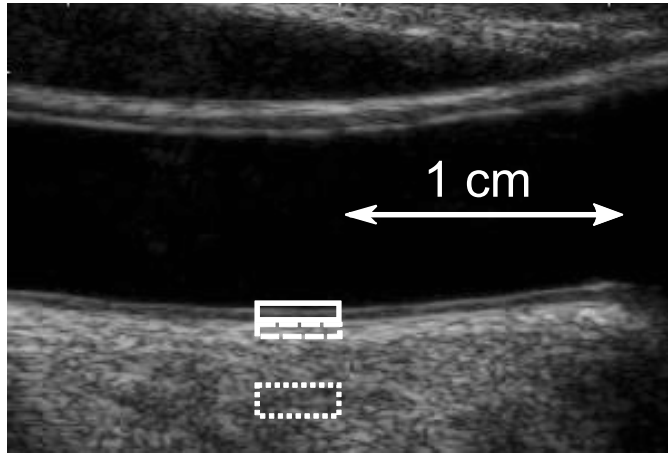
Ultrasound image of the common carotid artery. The typical locations of the regions of interest (ROI) used in the longitudinal motion-tracking are 1 cm before carotid bifurcation. Solid line, intima-media ROI; dashed line, adventitia ROI; dotted line, surrounding tissue ROI.
